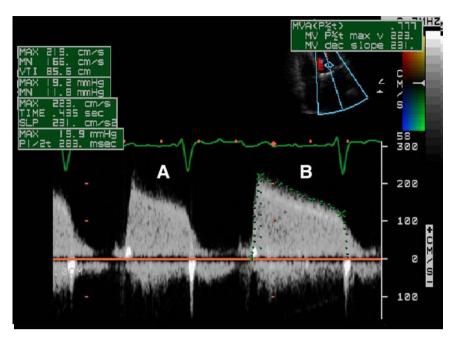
Measurement of pressure gradients in mitral stenosis. Tracing the continuous-wave Doppler velocity time integral (VTI) envelope across stenotic mitral valve gives maximum and mean pressure gradients.
